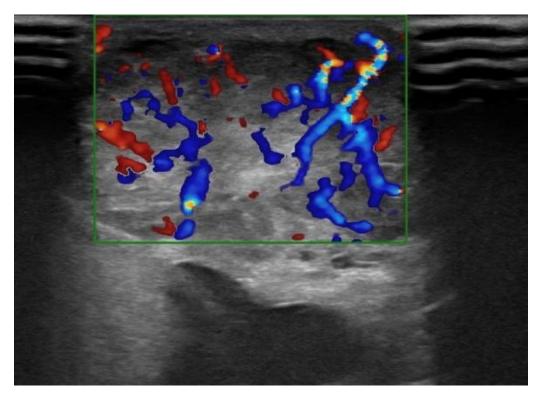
Colour Doppler USG image of leiomyosarcoma of scrotal wall
